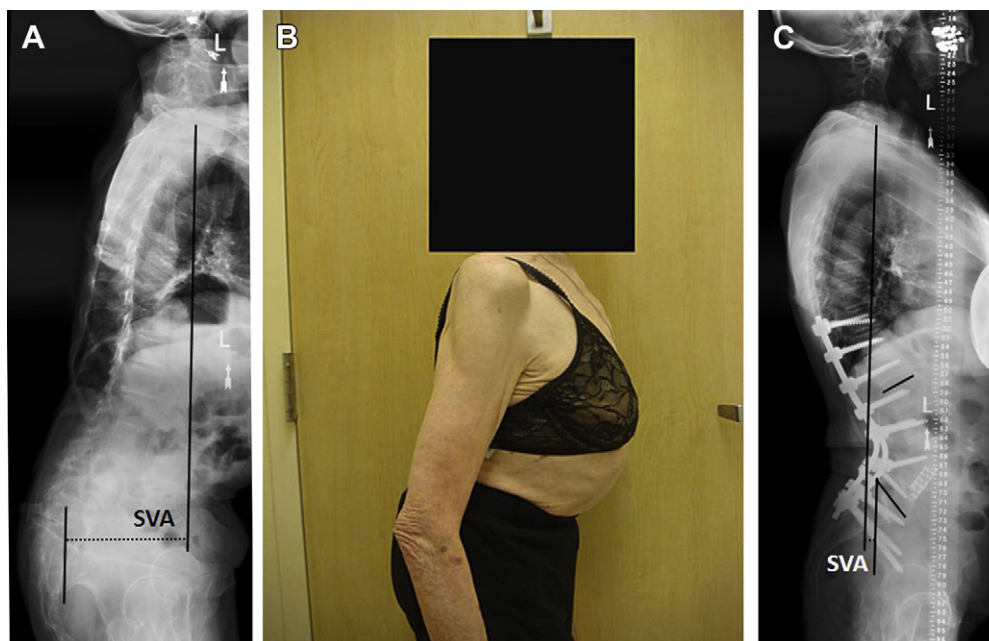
Clinical photograph and radiographs of a 52-year-old woman presenting with back pain and right lower extremity radicular pain. (A) Preoperative full-length lateral radiograph demonstrates positive sagittal malalignment and pelvic retroversion. The C7 plumb line and a vertical line drawn at the posterosuperior aspect of the sacrum are drawn with solid black lines. The horizontal distance between these is shown as a dashed line and is the sagittal vertical axis (SVA). Findings on clinical assessment include a pronounced forward posture and pelvic retroversion on side profile (B). Postoperative full-length sagittal radiograph following instrumented correction of the deformity (C). Note that the C7 plumb line falls within 2 cm of the posterosuperior aspect of the sacrum, reflecting good restoration of sagittal spinal alignment.
